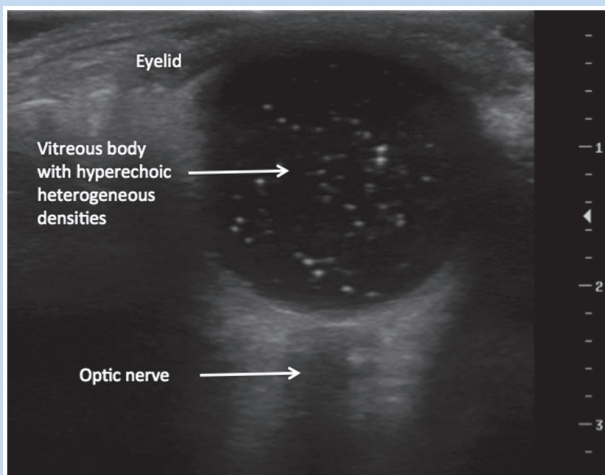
Diagnostic ultrasound image of a vitreous hemorrhage. The vitreous hemorrhage appears as hyperechoic, heterogeneous densities within the anechoic vitreous body. Having the patient move his eyes horizontally will produce a “swirl sign,” and the densities will swirl within the globe. Top of image, superficial; bottom of image, deep; left side of image, medial; right side of image, lateral.
